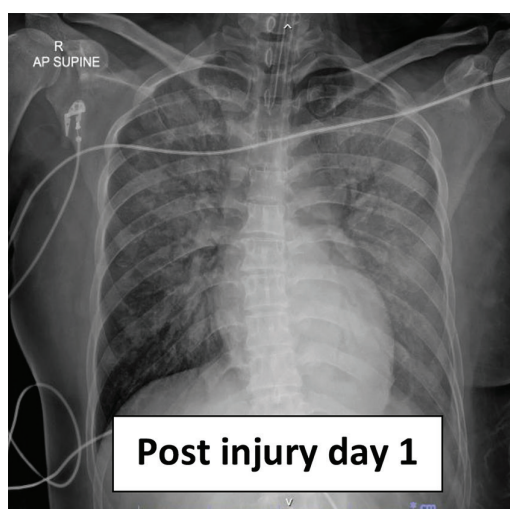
Chest X-ray with perihilar infiltration
